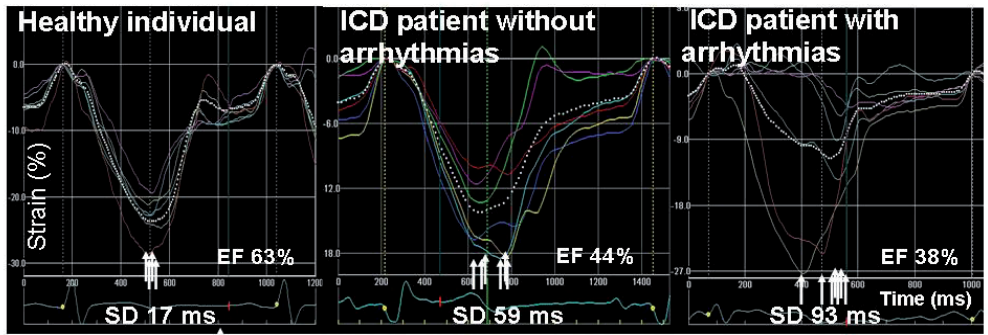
Mechanical dispersion by strain echocardiography in a healthy individual and ICD patients without and with follow up arrhythmias.
